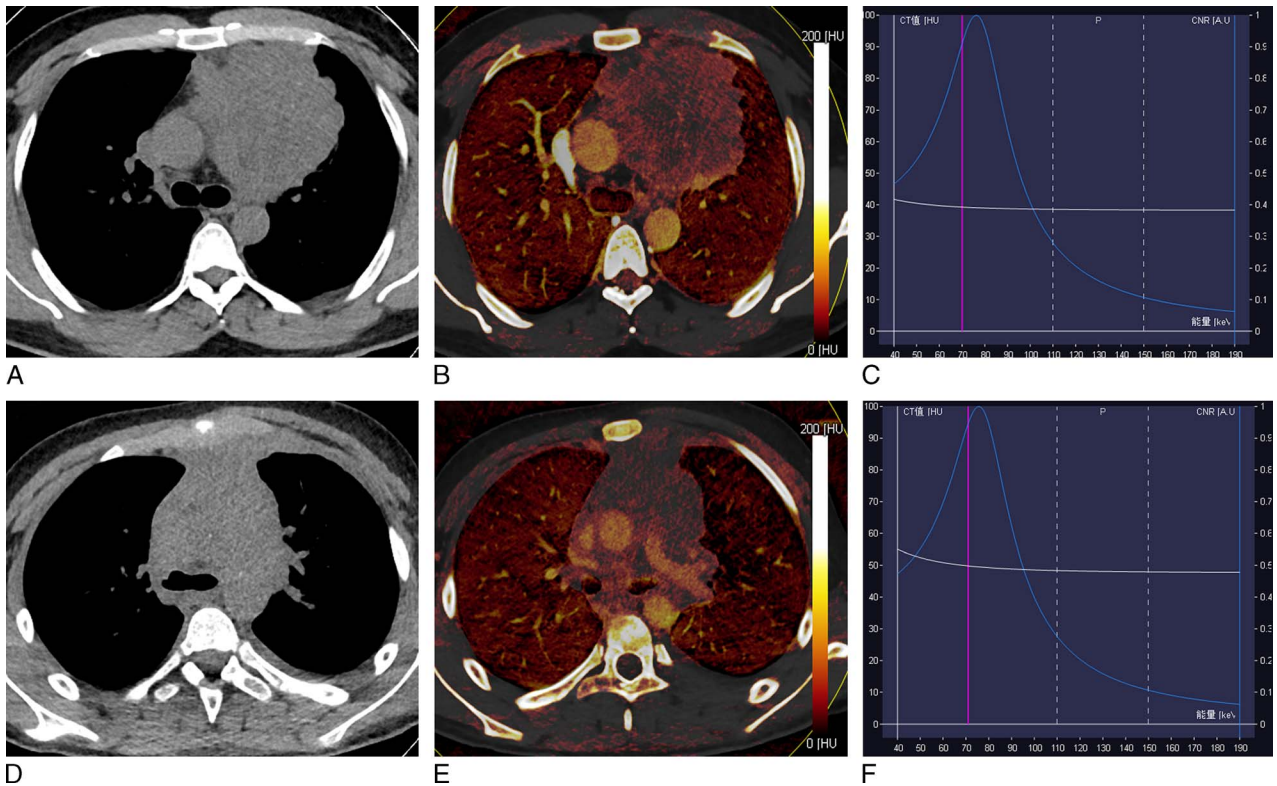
Dual-energy computed tomography images of representative cases with thymic carcinoma and lymphoma. A–C, Thymic carcinoma (squamous cell carcinoma): (A) axial VNC CT image shows anterior mediastinal mass with irregular contour, blurred fat layer of peritumor, and irregular interface with an absent space between tumor and pleura. B, Axial iodine overlay image shows heterogeneously mild to moderate iodine color in tumor, and IHU, IC, and MHU values in venous phase were 10.9 HU, 0.5 mg/mL, and 53.3 HU, respectively; (C) graph of virtual monochromatic HU curves for the same region of interest locations shows less steep descending curve in tumor. D–F, Thymic lymphoma (T lymphoblastic lymphoma): (D) axial VNC CT image shows anterior mediastinal mass with absent fat layer of peritumor, thickening pleura interface, and absent space between tumor and mediastinal blood vessels. E, Axial iodine overlay image shows mild iodine color in tumor, and venous phase IHU, IC, and MHU values were 5.8 HU, 0.7 mg/mL, and 54.1 HU, respectively; (F) graph of virtual monochromatic HU curves for the same region of interest locations shows less steep descending curve in tumor. Figure 2 can be viewed online in color at www.jcat.org.
